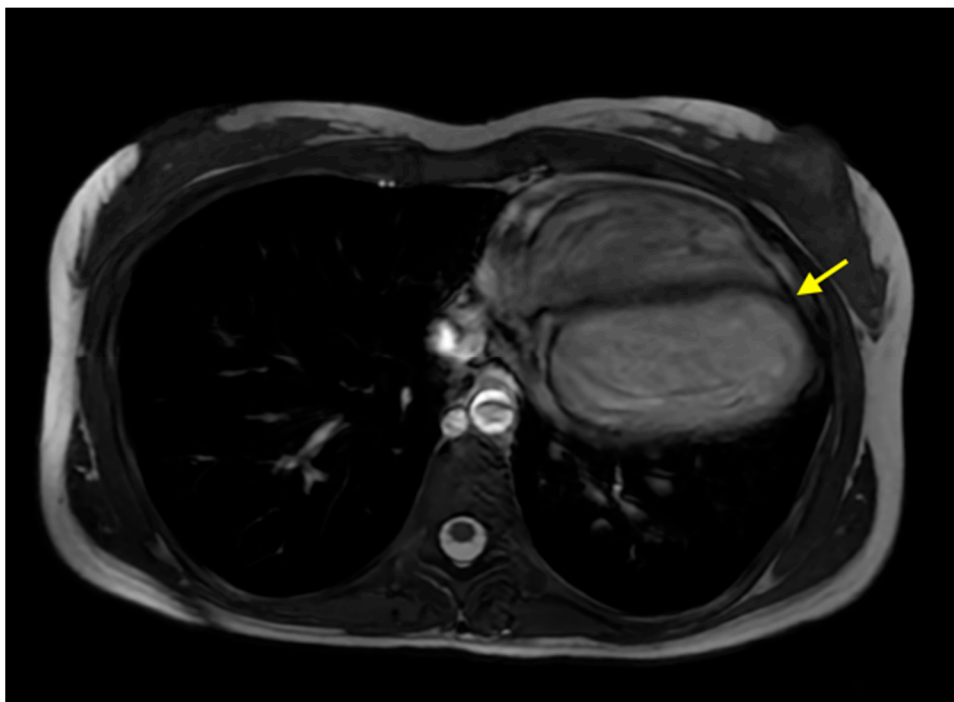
Cardiac MRI in the axial plane, demonstrating leftward displacement of the heart with rotation of the cardiac apex (yellow arrow).
